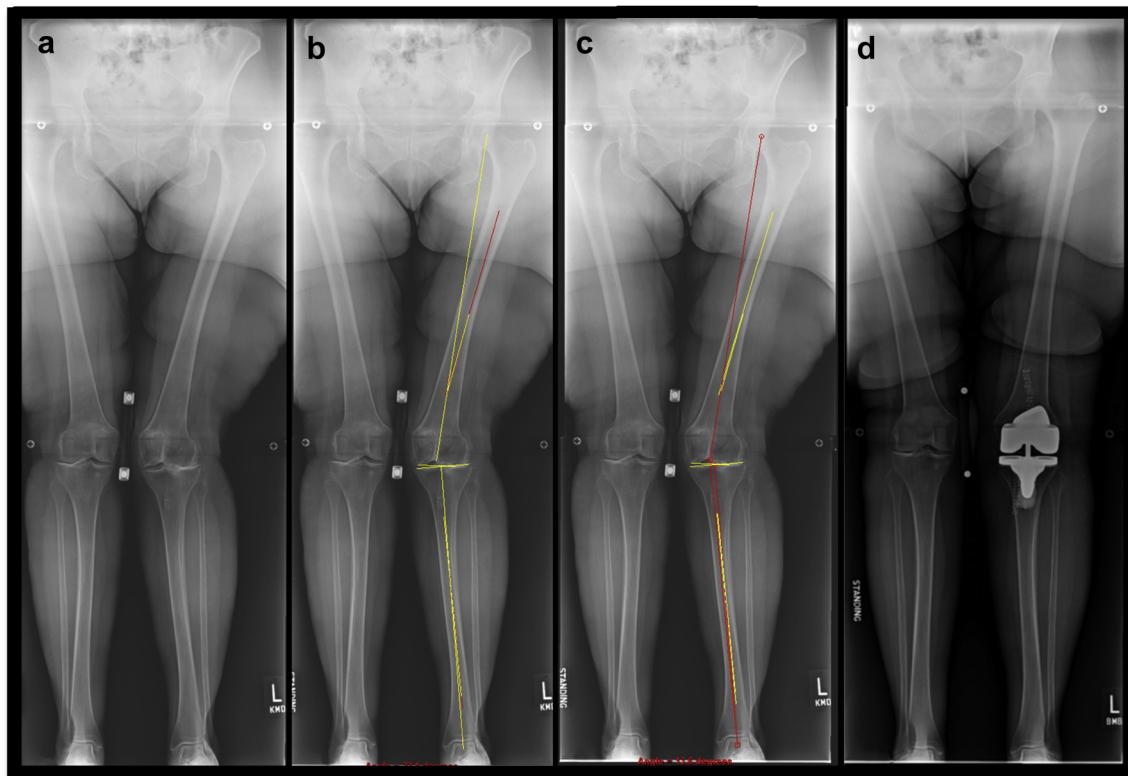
(a) Preoperative long-standing radiographs demonstrating valgus deformity of the left lower extremity. (b) Anatomic tibiofemoral angle of 22.1° (red lines). (c) Mechanical hip-knee-ankle angle of 13.6° (red lines). (d) Postoperative long-standing radiographs demonstrating correction of the deformity (this patient required a type 3 release of the lateral soft tissue contractures) and use of a constrained articulation.
